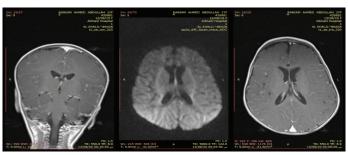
MRI brain of index case at ten month
